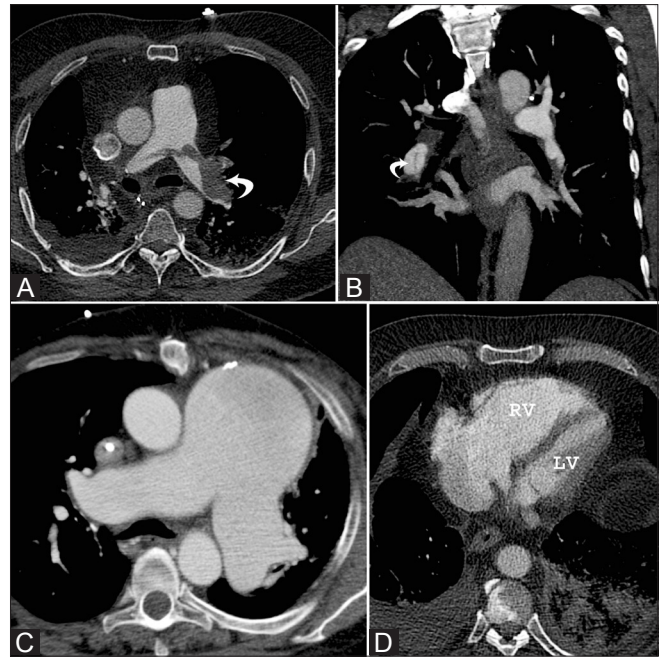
(A–D): Pulmonary artery abnormalities. Axial CT scan (A) shows a large intraluminal filling defect in the left pulmonary artery (arrow) consistent with acute pulmonary embolus. Coronal reformatted CT image (B) shows a linear web in the right interlobar artery, consistent with chronic pulmonary embolus. Axial CT image (C) in a patient with history of recurrent pulmonary embolism shows severely dilated pulmonary arteries, consistent with pulmonary arterial hypertension. Axial CT image (D) in a patient with acute pulmonary embolism and pulmonary hypertension shows dilatation of the right ventricle and bowing of the inter-ventricular septum to the left side, consistent with RV strain
